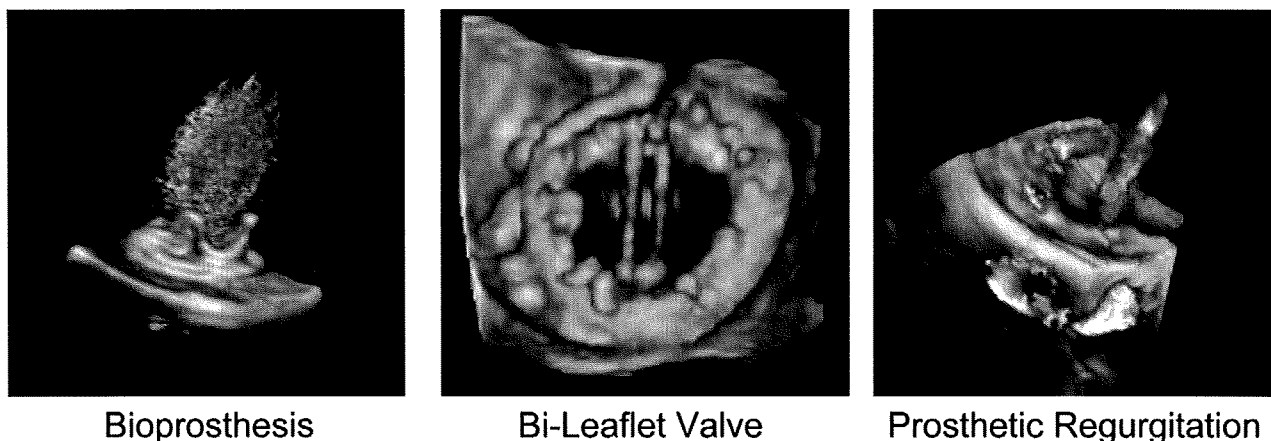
Examples of 3D echocardiography and Doppler images of a bioprosthetic valve (*left*), bileaflet mechanical valve in the mitral position from the LA view (Video 17, [video clips online](#)), and a prosthetic valve with regurgitation.
